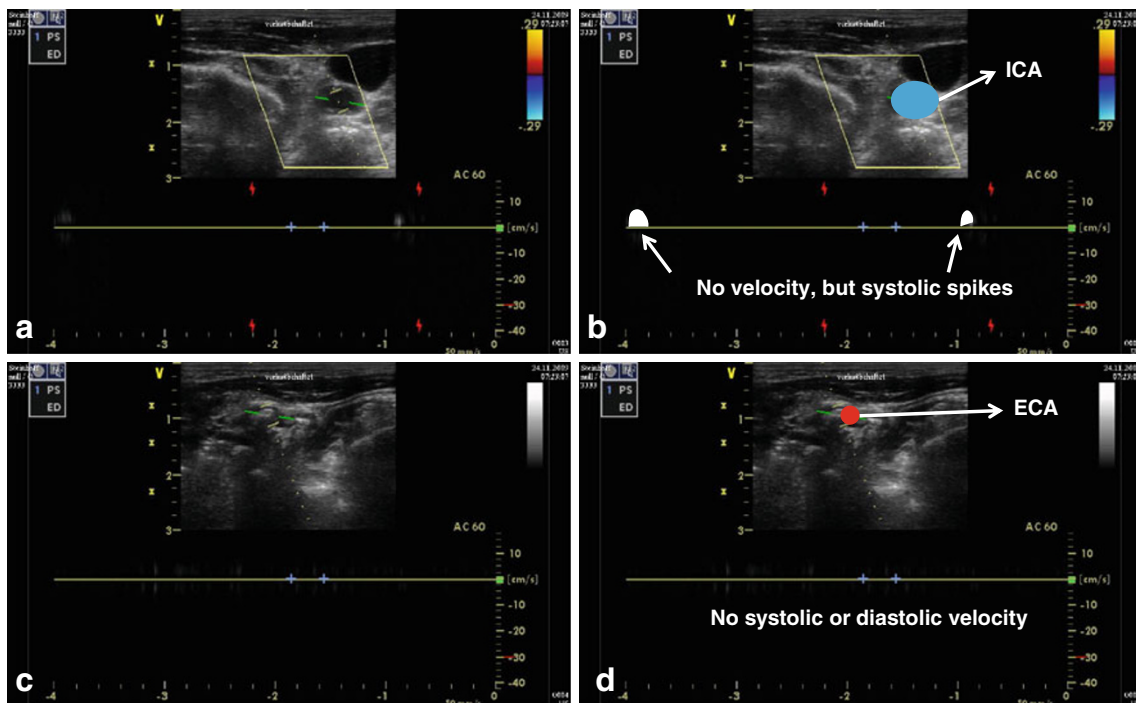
Example of duplex sonography a patient during resuscitation with pulseless electrical activity (no wall motion). Extracranial internal carotid artery (ICA), external carotid artery (ECA). Flow
